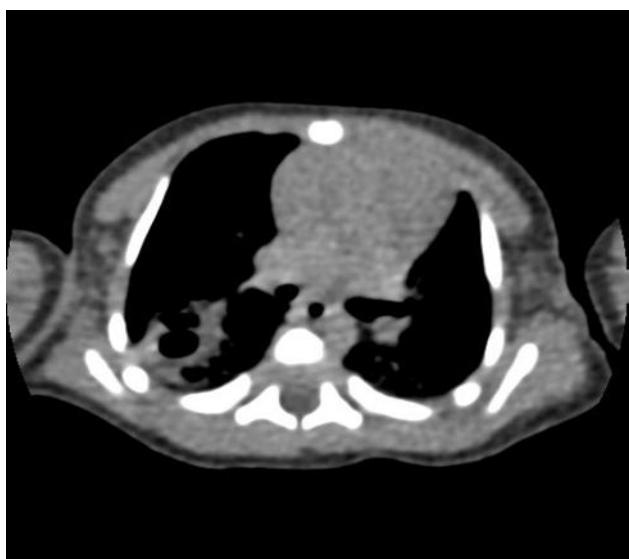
Axial non-contrast HRCT image demonstrating multiple cystic lucencies in the affected lung parenchyma with intervening soft-tissue attenuation.
